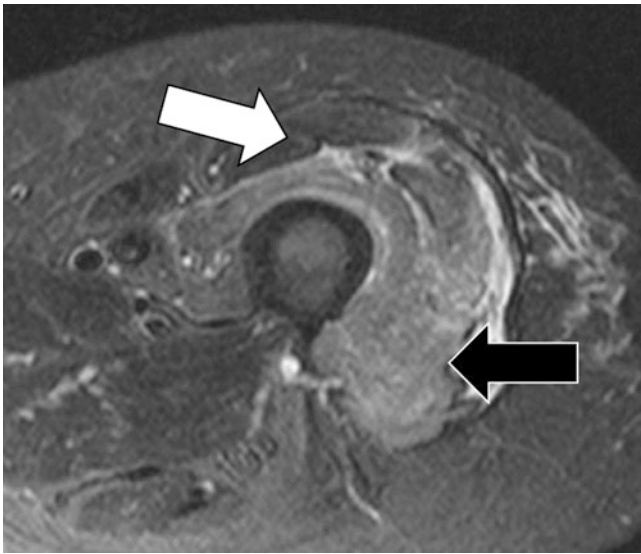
Axial fat-saturated STIR MR image of the left thigh in a patient with inclusion body myositis and acute pain. Notice the diffuse edema in the anterior compartment musculature (black arrow) with notable sparing of the rectus femoris (white arrow)
